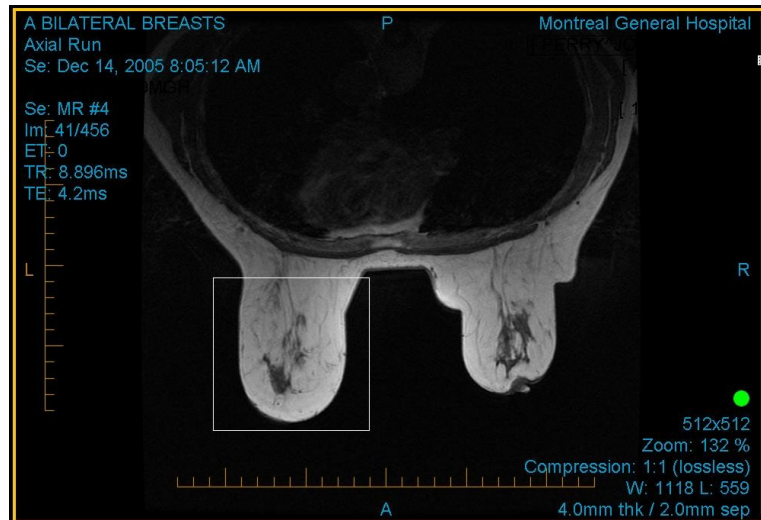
An MRI slice with a white square around the area of interest.
